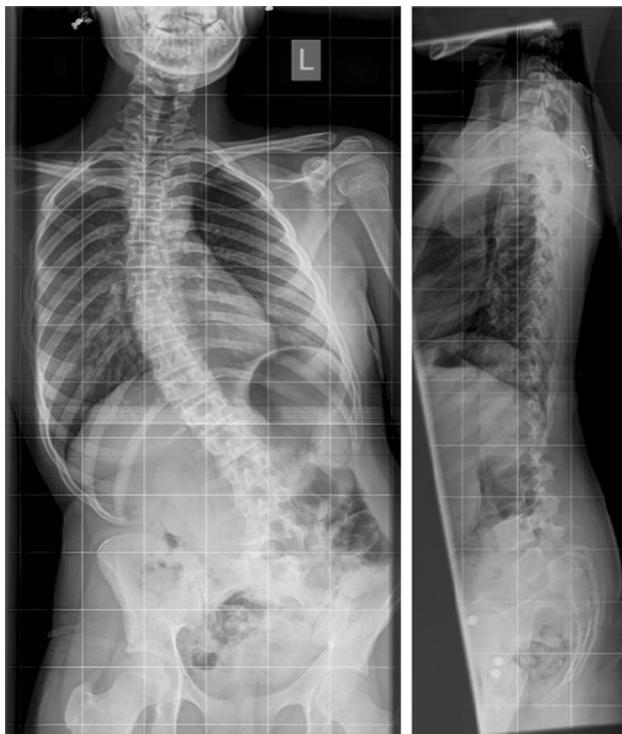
AP and lateral radiograph demonstrating spondylolisthesis and scoliosis
